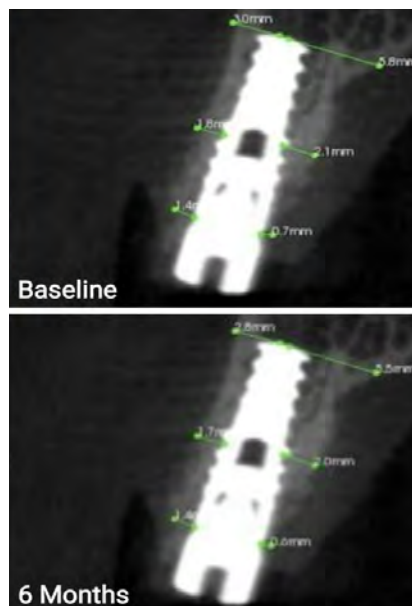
Buccal and Palatal CBCT measurements recorded at Baseline (Day 0) and 6 Months
